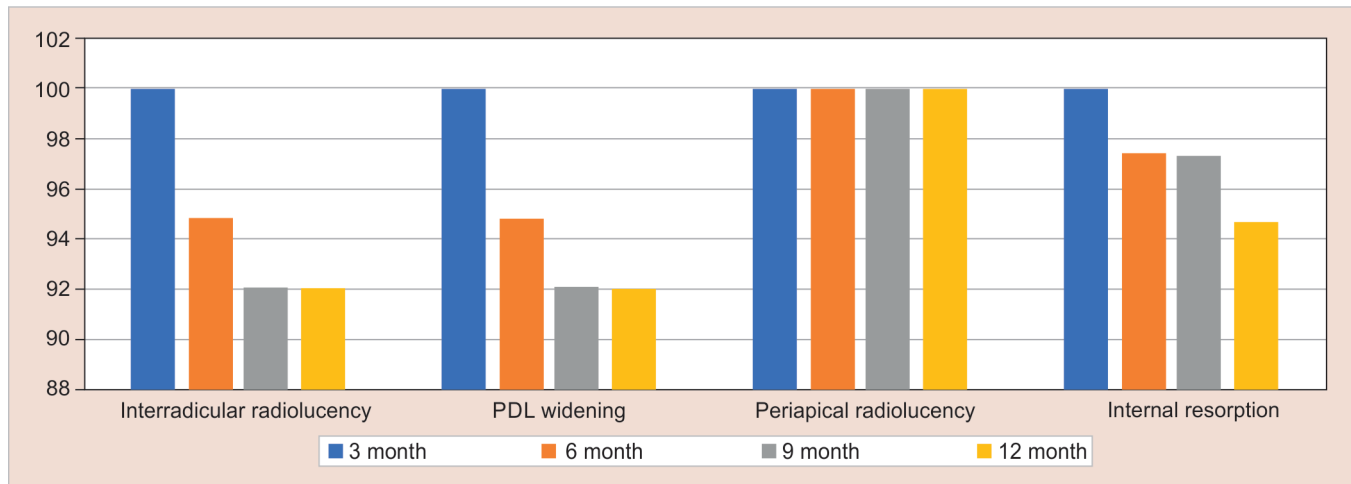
Radiographic evaluation at 3, 6, 9, and 12 months
